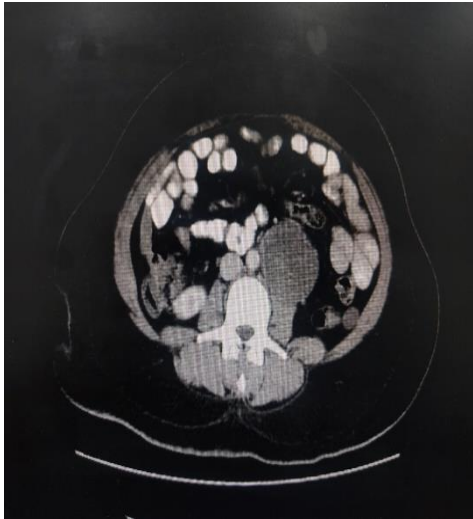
Axial view of abdominal CT showing left retroperitoneal mass.
